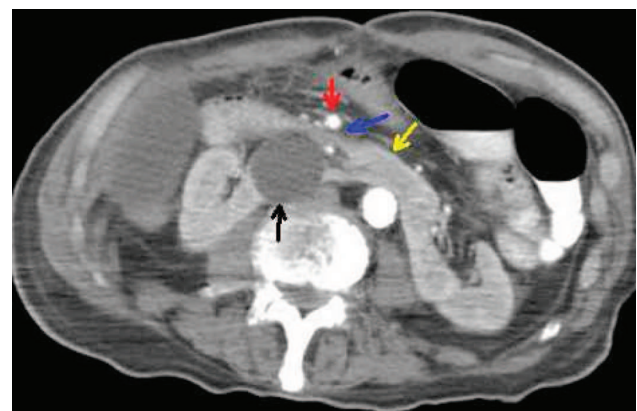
Axial computed tomography (CT) showing duodenal dilation proximal to the level of the third part (blue arrow) which is compressed by the close proximity of superior mesenteric artery (red arrow) to the renal cyst (black arrow) and isthmus (yellow arrow) of the horseshoe kidney.
